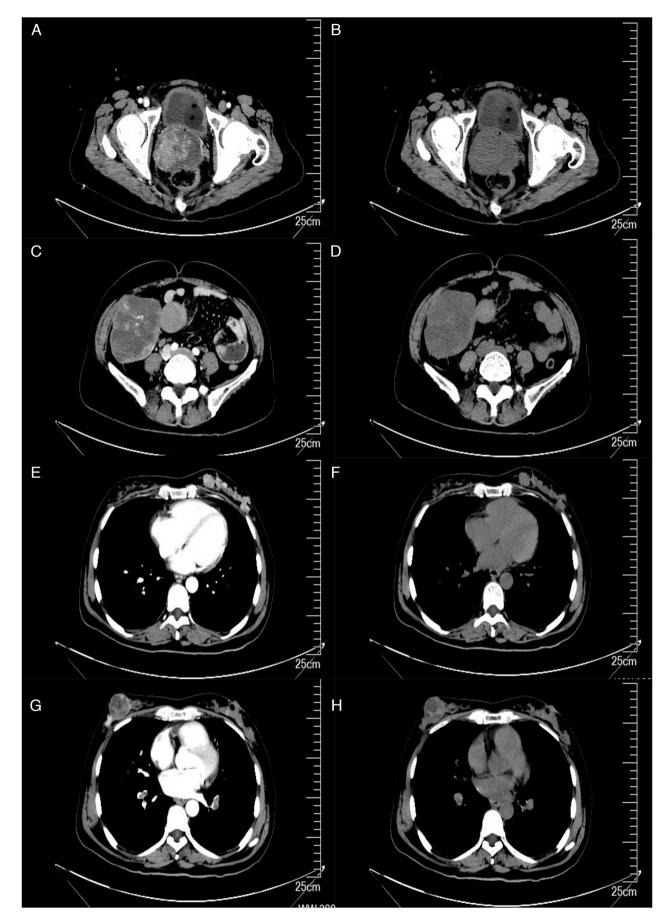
CT images of tumors at four sites. (A) Images of cervical lump on enhanced CT scan. (B) Images of cervical lump on routine CT scan. (C) Images of right abdominal lump on enhanced CT scan. (E) Images of left breast lump on enhanced CT scan. (F) Images of left breast lump on routine CT scan. (G) The images of right breast lump on enhanced CT scan. (H) The images of right breast lump on routine CT scan. (C) Transmission of the computerized tomography.
